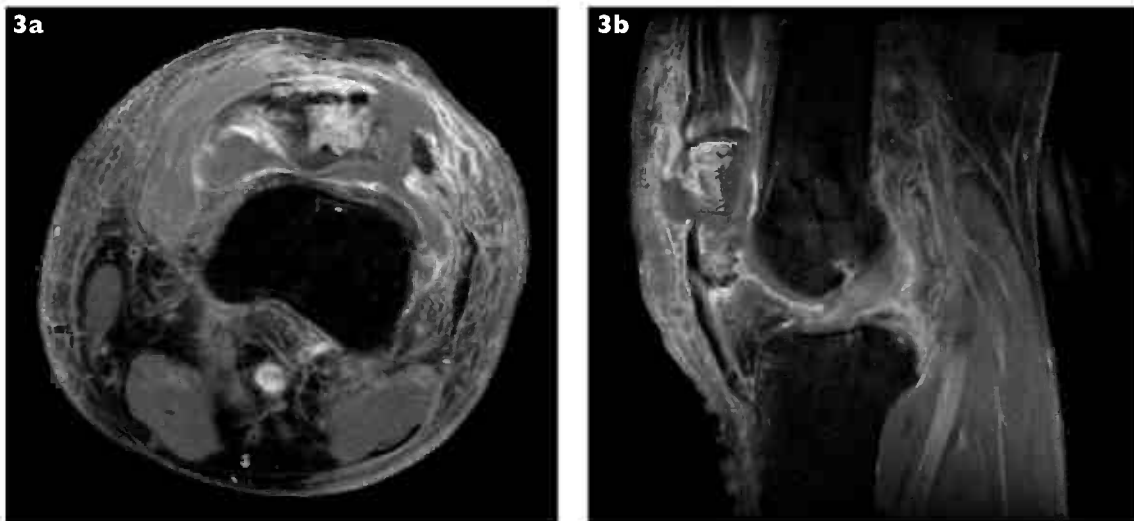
(a) Axial and (b) sagittal MR images of the left knee joint show fragmentation of the patella with tumorous replacement of the normal fatty marrow signal. There is a very large joint effusion with extension of the joint fluid into the surrounding prepatellar soft tissue.
